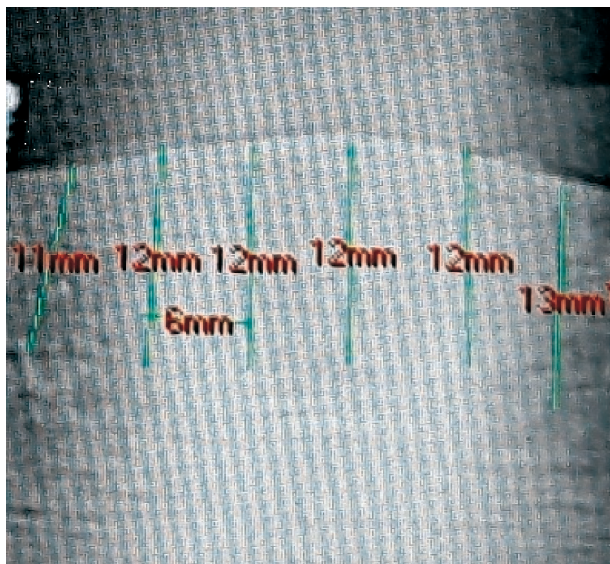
Vertical dimension of the alveolar ridge in the anterior mandibular region (orthopantomogram).
